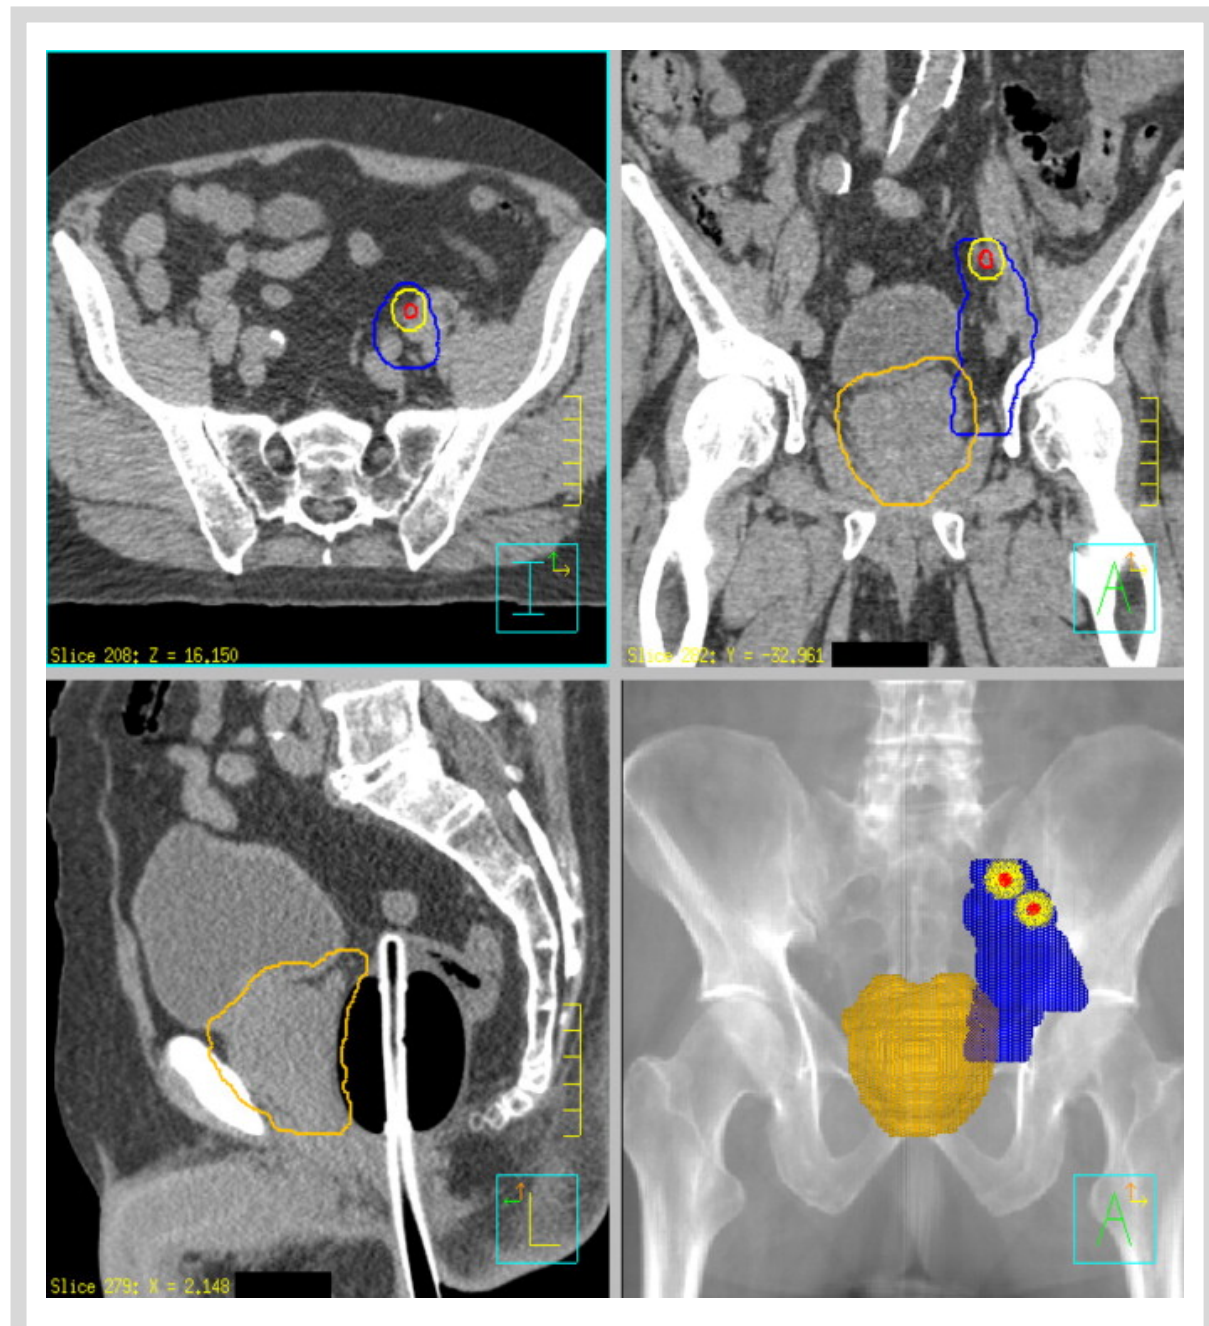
After identification of the pathological lymph nodes, the lymph nodes were delineated on the CT scan. These are shown in red. The PTV_{inn} is delineated in yellow, the PTV_e in blue, and the PTV_p in orange.
